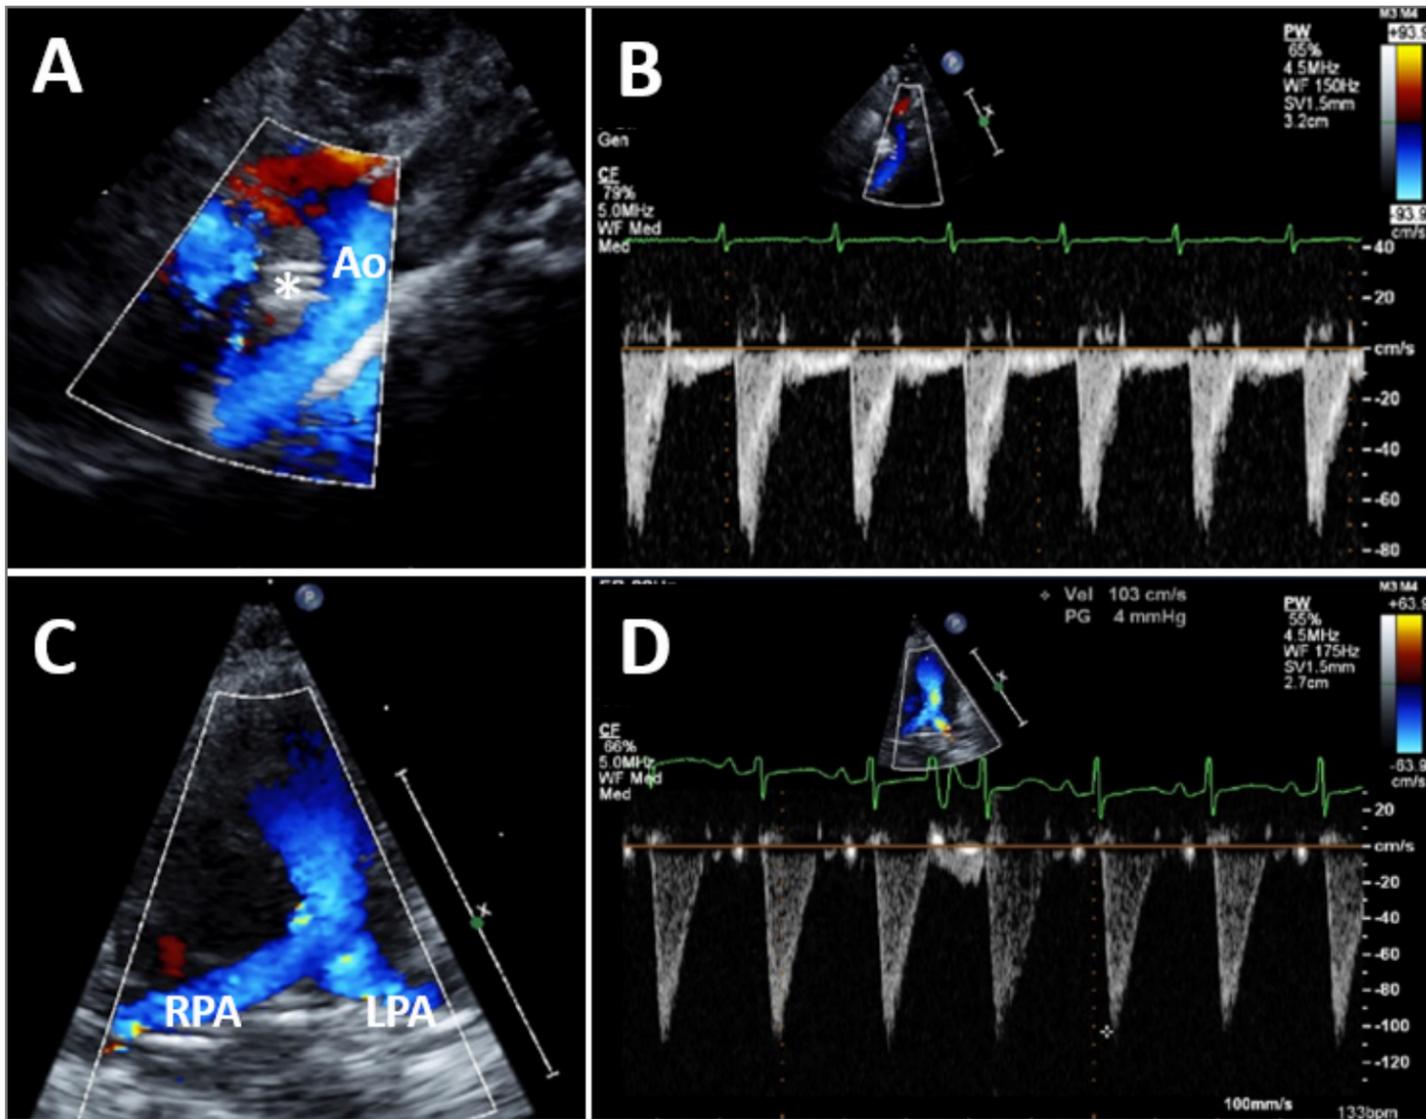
Echocardiography following deployment. The device (\*) remains well-positioned with no malrotation or protrusion into the Ao or LPA. Echocardiographic images using color (A,C) and spectral (B,D) Doppler show no residual ductal shunting, no obstruction to LPA or Ao flow, and normal Doppler flow profiles in these vessels.
